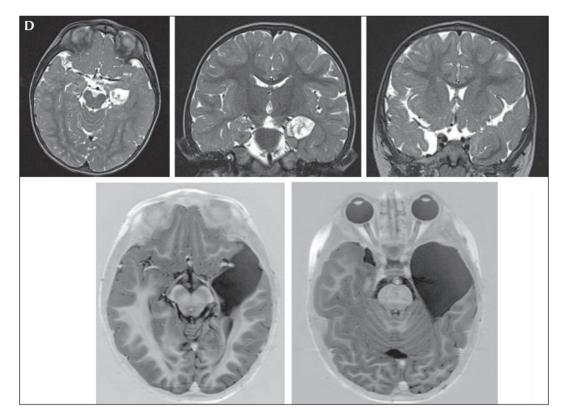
Patient 5. (D) Preoperative MRI showing left choroid plexus papilloma and hippocampal sclerosis and image postoperative examination (*continued*).
